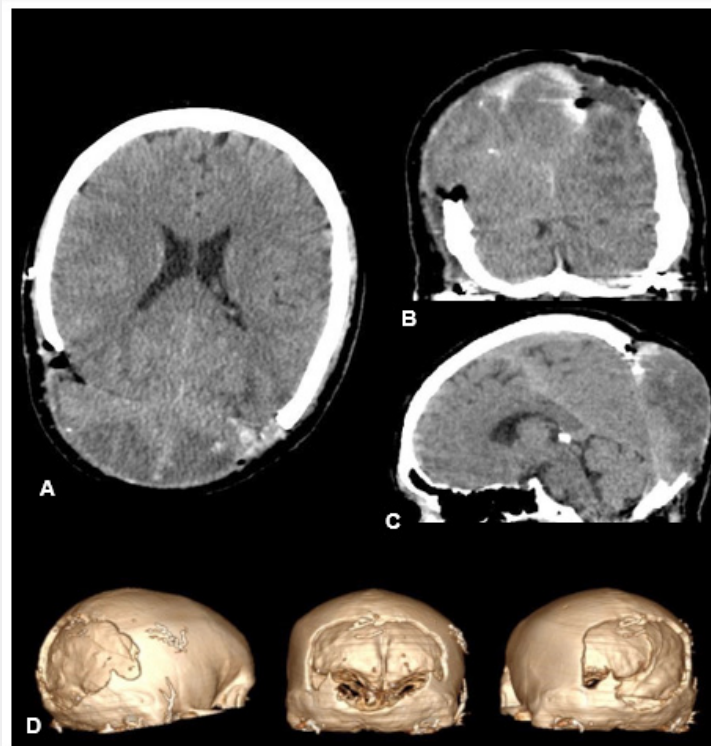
Simple CT scan of skull A, B and C Axial, Coronal and Sagittal sections, respectively, where there is evidence of a solution in the continuity of the bone table in the parieto-occipital region, lesion of extra-axial heterogeneous characteristics, with a dural interface and flattening of underlying structures. D. 3D reconstruction of the bone defect.
